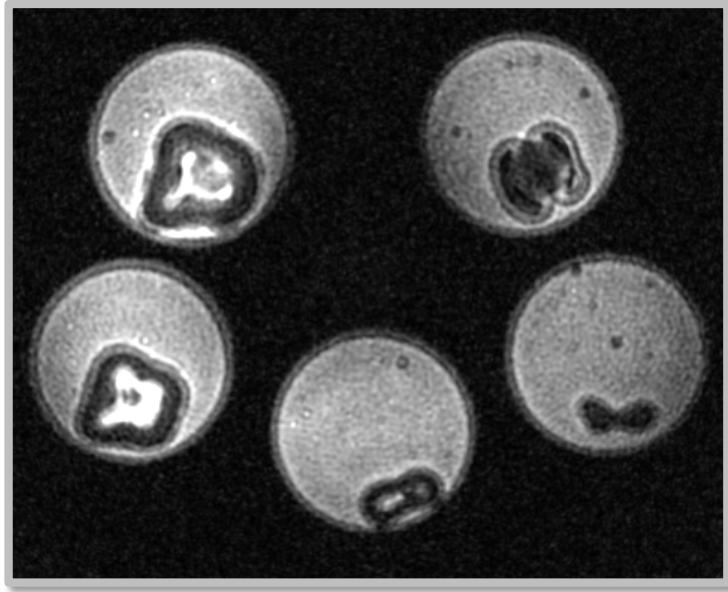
Selected axial slice of a raw SWIFT MRI prior to cropping the image to include only 1 tooth per image set. Note the variable focus within this image, producing an out-of-focus, double-line phenomenon. This phenomenon was taken into account when developing the MRI-based criteria for radicular crack/fracture presentation.
